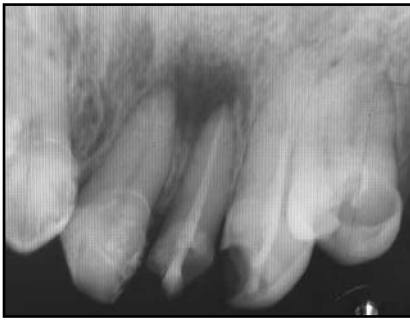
Radiographic image of 22, 3 months after MTA treatment
